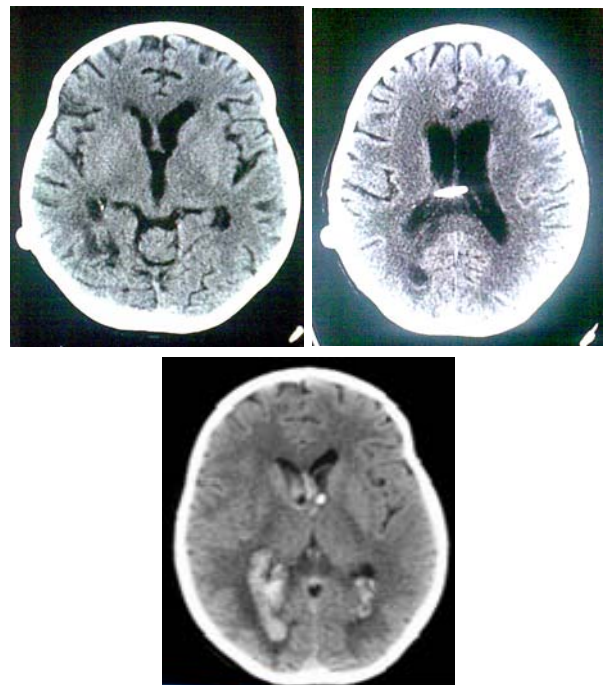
Brain CT with a VP shunt 2 months post haemorrhage showing complete resolution of blood.
